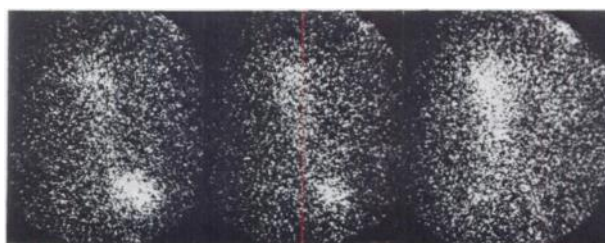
Serial scintiphotography (sequential scintigraphy) and OIH-single shot clearance in acute rejection.
